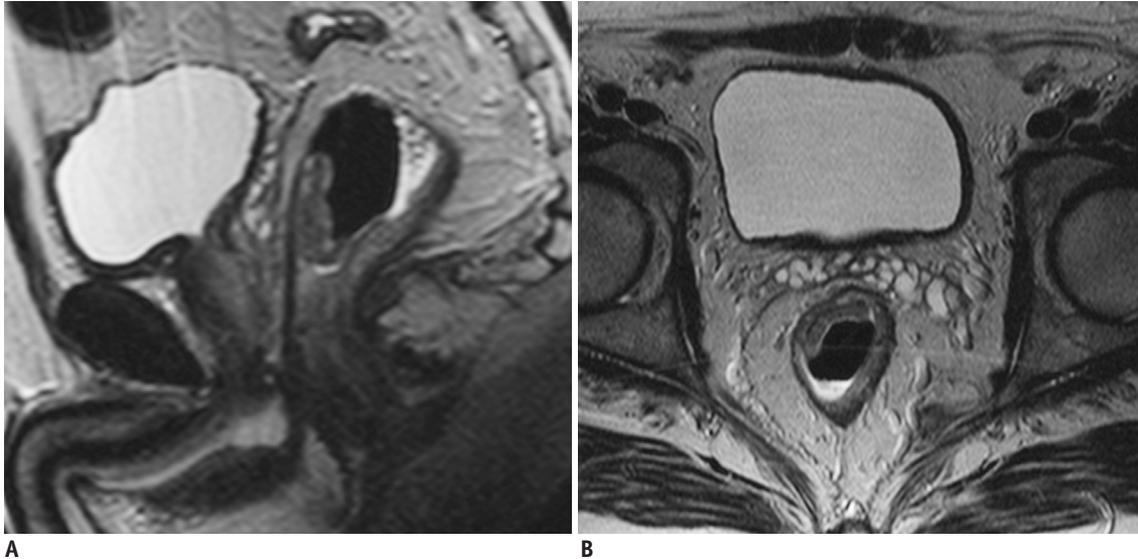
High-resolution Turbo Spin Echo T2-weighted scans on sagittal (A) and axial plane (B) show T2-stage low rectal cancer. Muscular layer appears normal both on sagittal and axial scan and insufflation of rectal lumen does not modify detection of mesorectal fat tissue anteriorly.
